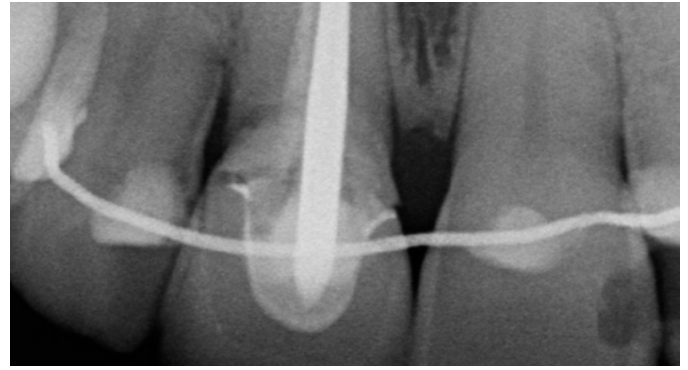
Preoperative radiograph confirming root and post position
